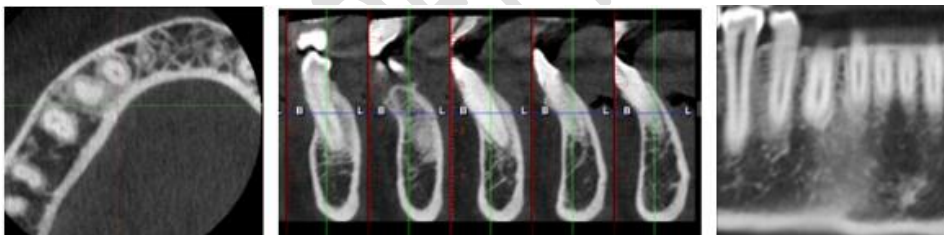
CBCT reveals no crestal and trabecular bone changes
